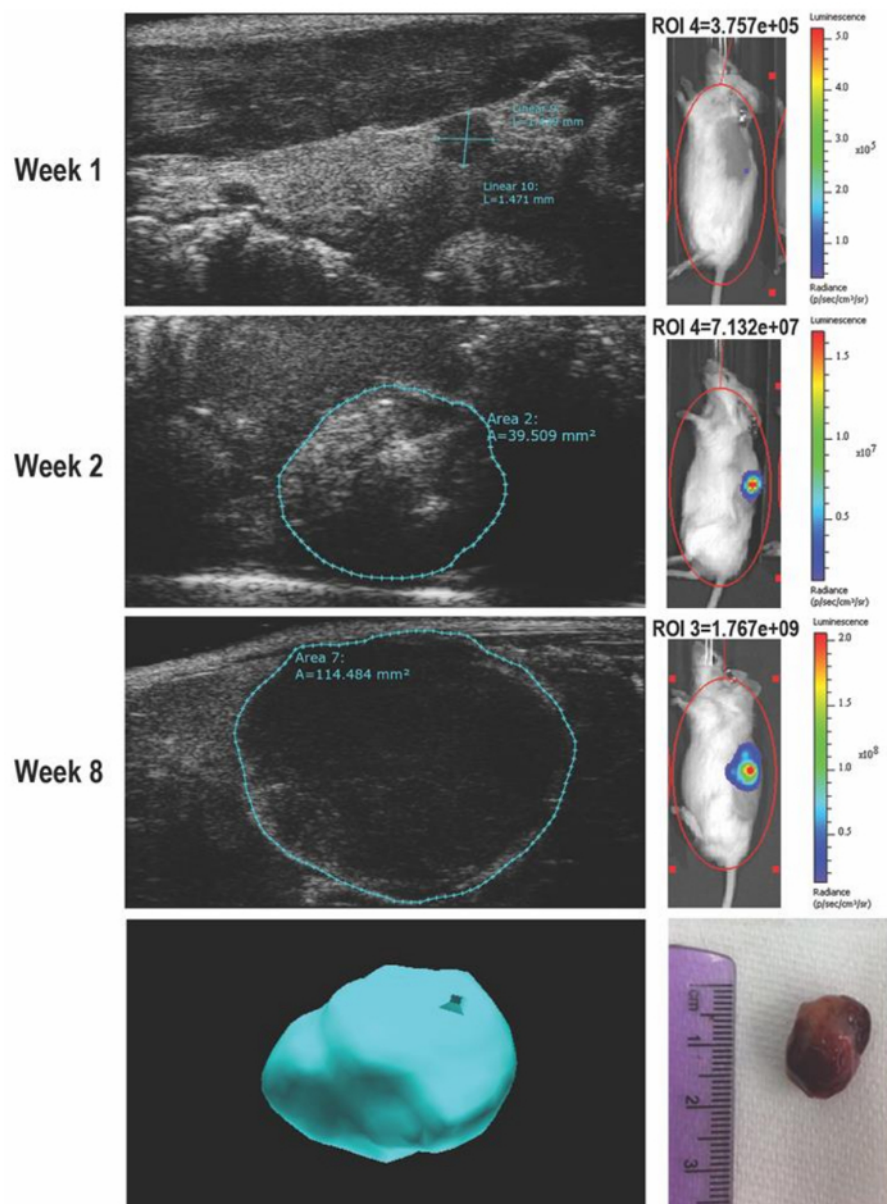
In vivo* ultrasound imaging of tumor engraftment and growth. Ultrasound imaging monitored *in vivo* tumor progression. Ultrasound images and corresponding bioluminescence images at one, two and eight weeks are shown. At one week, engraftment was visualized in both imaging modalities. Tumor area and volume were calculated using ultrasound imaging. 3D ultrasound images mirrored excised tumors at the completion of the study. This figure has been modified with permission from Van Noord, R.A. *et al.*¹¹. [Please click here to view a larger version of this figure.](#)
